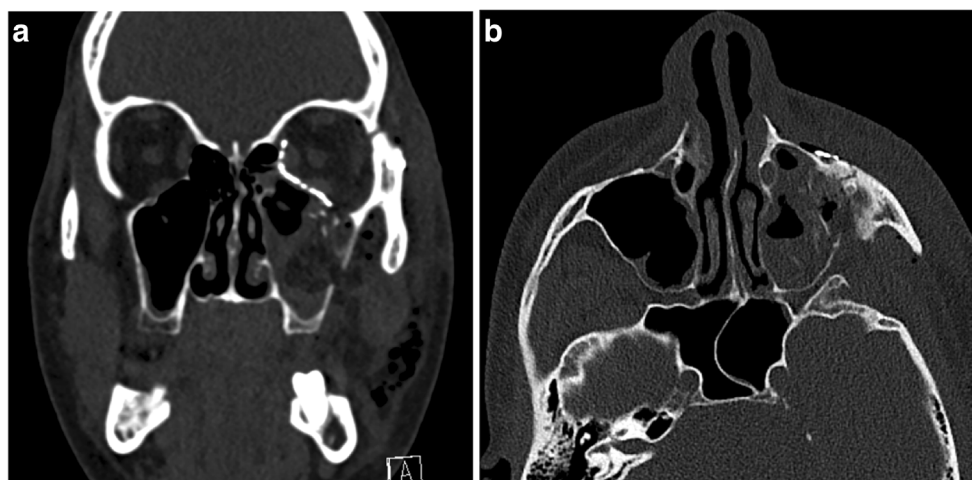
a CT following internal orbital reconstruction in a 24-year-old man who sustained an orbital blowout fracture after a motor vehicle collision. Images were acquired using a low-dose protocol at 20 mAs and 100 kVp. A soft tissue kernel was employed using a state-of-the-art dual-source 128-detector row scanner (Br40, Siemens Force; Siemens AG, Forchheim, Germany), which maintained excellent soft tissue contrast within the orbital contents, clearly displaying the optic nerve and extra-ocular muscles as distinct well-defined structures surrounded
